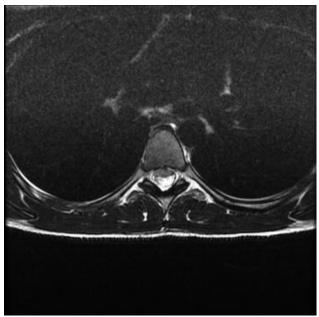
Spinal MRI: axial T2 section passing through T5, showing the spinal cord drawn forward. No visible CSF between the vertebral body and the spinal cord
